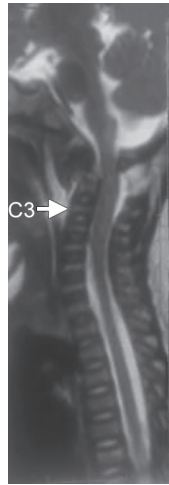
T2 image of MRI cervical spine suggestive of fracture of dens of C2 with posterior displacement of the body of C2 causing compression over the cervicomedullary junction, cord contusion, and edema up to the C4 vertebral level. Prevertebral hematoma from base of the skull to the C4 vertebral level with widening of space between the posterior arch of C1 and C2 with adjacent edema representing ligament injury was seen
